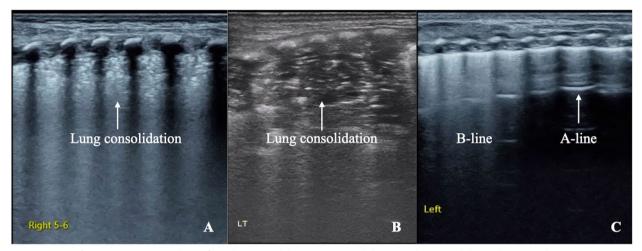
Weaning from MV in patients with significant lung consolidation. We can withdraw MV when consolidation disappeared in patients with lung consolidation as the main ultrasound manifestation, such as RDS (A), pneumonia or atelectasis (B) even if the image has not fully returned to normal (C)
